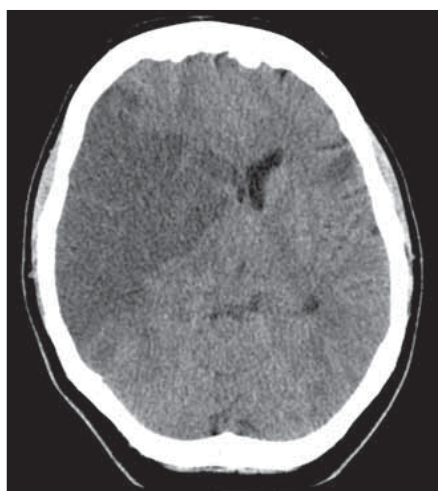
CT of the brain indicating an expansively behaving ischemia in the right hemisphere.
